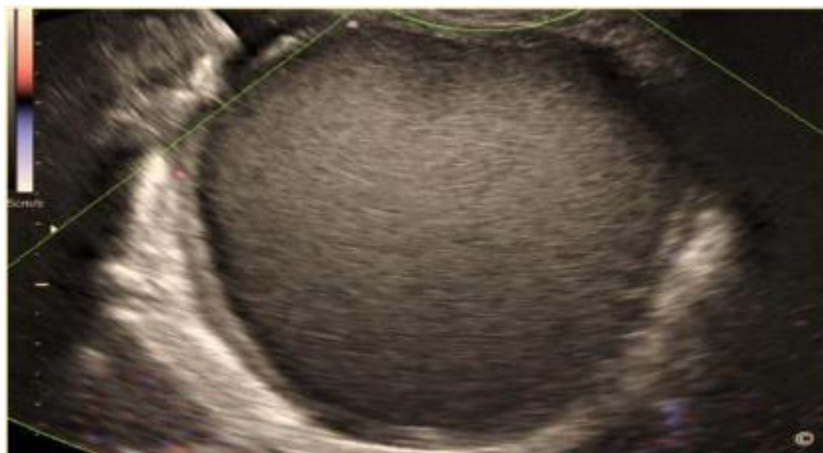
Transvaginal US with color Doppler of an endometrioma showing a unilocular mass with ground glass appearance. Note the absence of vascularity within the content of the mass on color Doppler (15).
